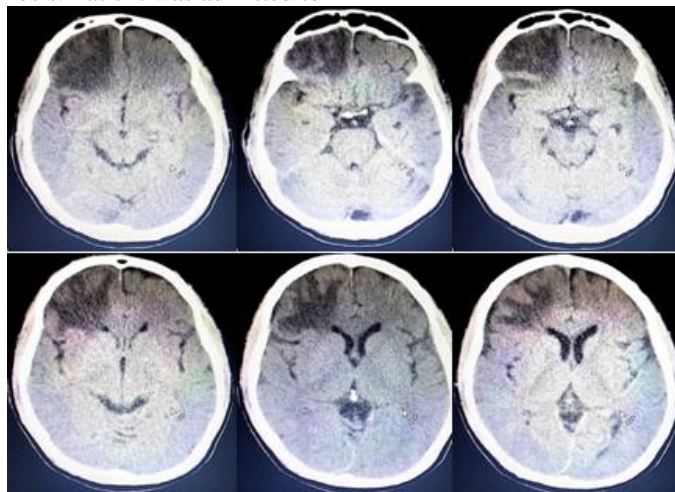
Head CT Scan without contrast shows perifocal tentacle and edema in the right frontal lobe
